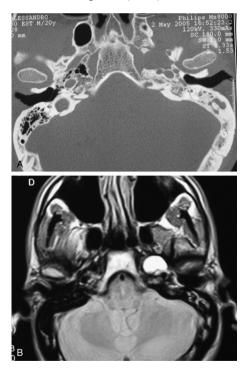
Magnetic resonance fast spin echo sequences of patient affected by left PA CG, managed by wait and see policy. (A) Computed tomography of year 2005. (B) Magnetic resonance scan of year 2008.
